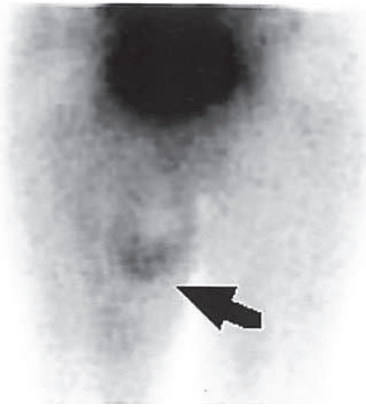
Planar ^{201}Tl (A) and coronal T1-weighted magnetic resonance (B) images of a patient presenting with conventional grade I chondrosarcoma of the pelvis (patient number 9). Increased ^{201}Tl uptake was not observed in the lesion corresponding to the tumor location disclosed by intermediate signal intensity on the magnetic resonance images (*arrows*).
